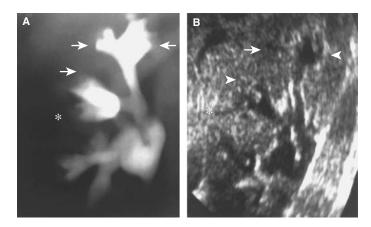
(A) Tomographic intravenous pyelography of an 18-year-old patient with abdominal pain and hematuria. Papillary necrosis is evident from blunted medullary cavities, especially the upper pole (arrows). The bases of the calyces are preserved. The middle pole calyx has a possible sinus tract (*). (B) Ultrasonographic visualization of the same kidney. The middle pole exhibits deep extensions into the papilla, probably sinus tracts, typical of the 'papillary' form of RPN. The arrows point to corresponding areas. (Reproduced with permission from Pediatric Nephrology. Barratt TM, Avner EA, Holliday MA (editors). Baltimore: Williams & Wilkins; 1999: 497.)
